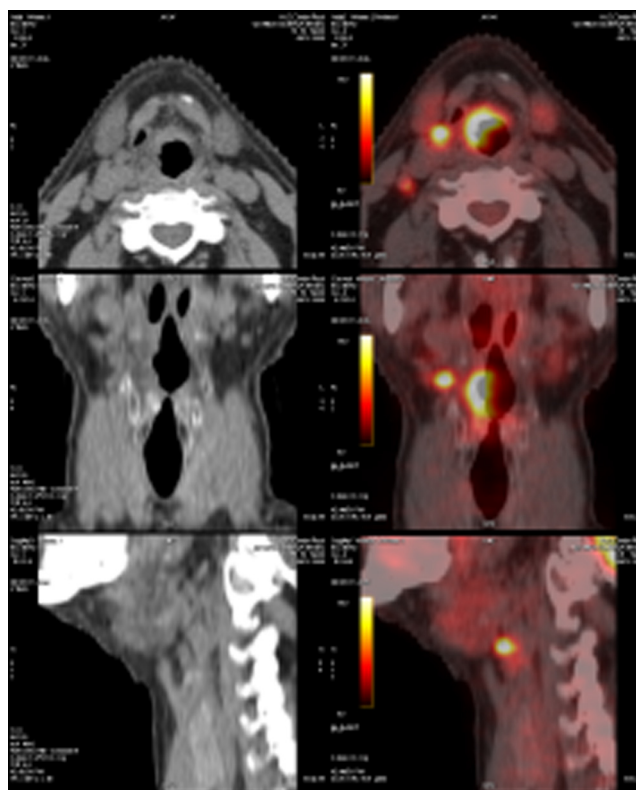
¹⁸F-FDG PET/CT on a patient with a supraglottic tumour. Avid tracer uptake helps to identify a positive lymph node located immediately lateral to the primary tumour. Physiologic uptake in the right vocal cords besides the fuzzy appearance of tumour borders due to low spatial resolution of PET image hamper the accurate delineation of tumour contours.
